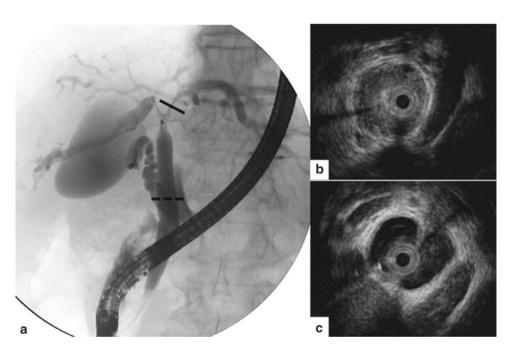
IgG4-related sclerosing cholangitis type 4. (a) Endoscopic retrograde cholangiography findings. Smooth stenosis is found in the hilus. (b) Intraductal ultrasonography findings at the left hepatic bile duct (seen at the *underline* in 9a). Thickened bile duct wall is depicted
